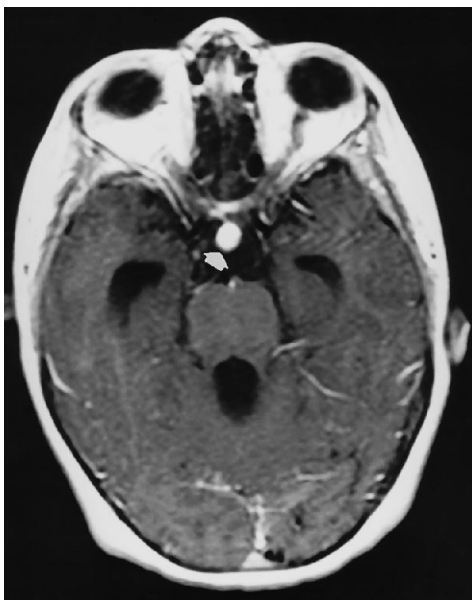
Contrast-enhanced axial T1-weighted spin-echo image (366/11) before treatment shows a markedly enhanced and thickened pituitary infundibulum (*arrow*) without cranial leptomeningeal enhancement.
